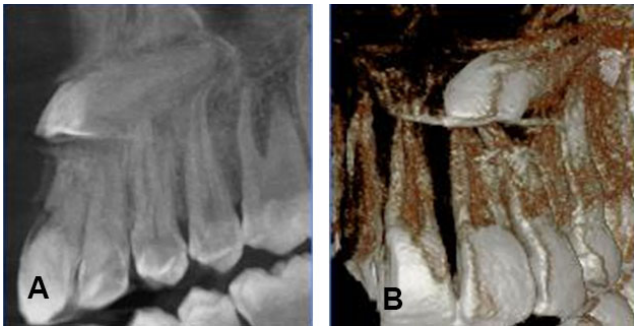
A scanned CBCT view image with sever resorption up to 3-4mm at apex of central and lateral incisors. a, sagittal view. b, coronal view.
